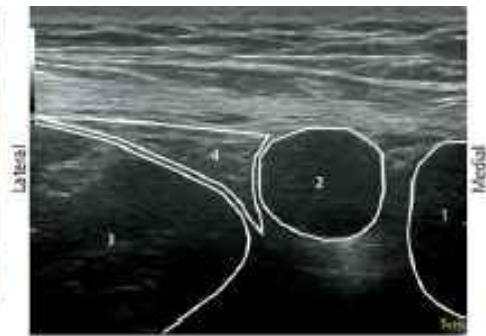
Ultrasound image: ultrasonographic view of primary landmarks
